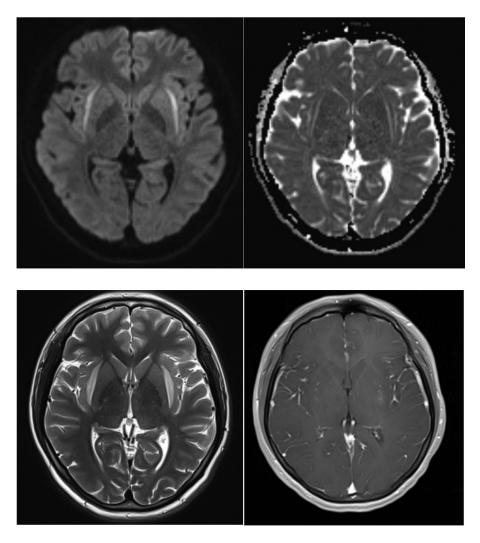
Axial DWI and T2 images reveal high signal intensity in the bilateral claustrum, which corresponds to elevated ADC values. Axial T1-contrast images show mild brain edema with linear enhancement in the bilateral claustrum.
